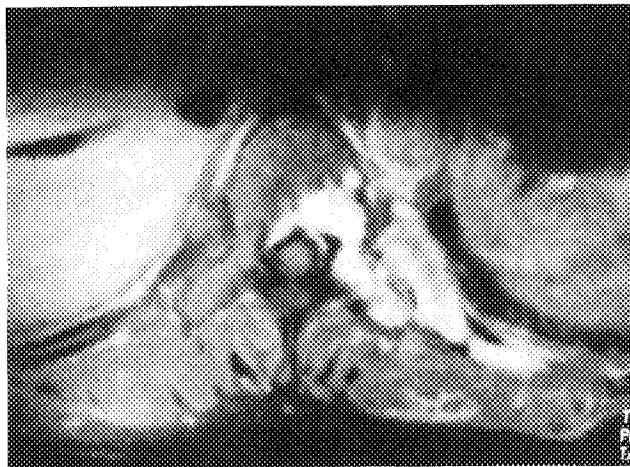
Axial gadolinium-diethylene-triamine pentaacetic acid-enhanced magnetic resonance image showing no displacement of the spinal cord.
